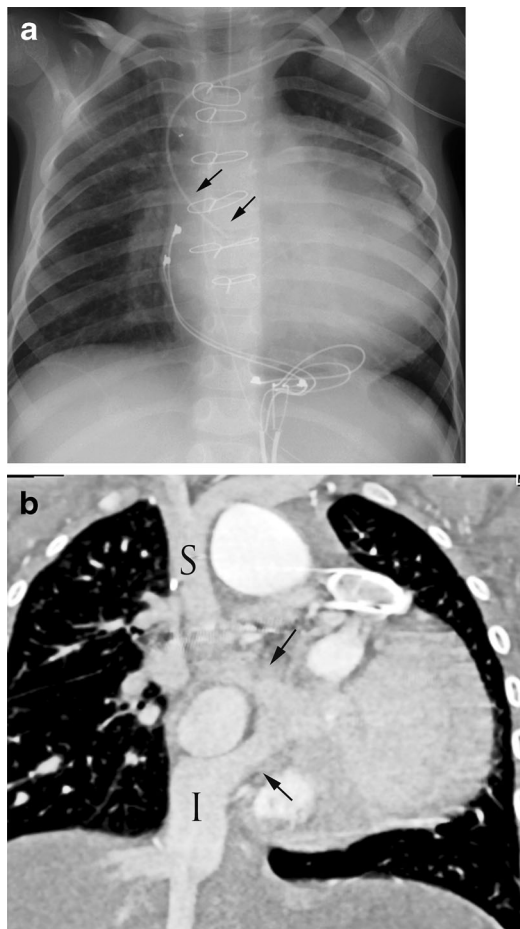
Venous catheter location mimicking arterial placement in a 4-year-old boy with repaired transposition of the great vessels. a Anteroposterior chest radiograph shows leftward curvature and left-side tip position of the venous catheter (*arrows*), resembling arterial placement. b Coronal reconstruction of contrast-enhanced CT shows Mustard intra-atrial baffle with superior and inferior limbs (*arrows*) joining superior (*S*) and inferior (*I*) vena cavae to the anatomical left ventricle
